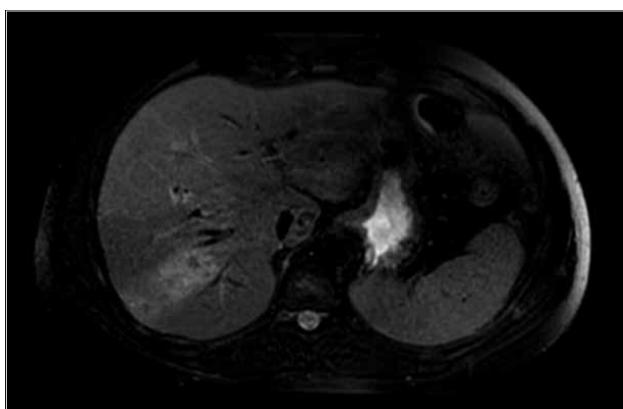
Highly hyperintense lesions are observed in the posterior segment of the right lobe on axial T2*WI MRI
